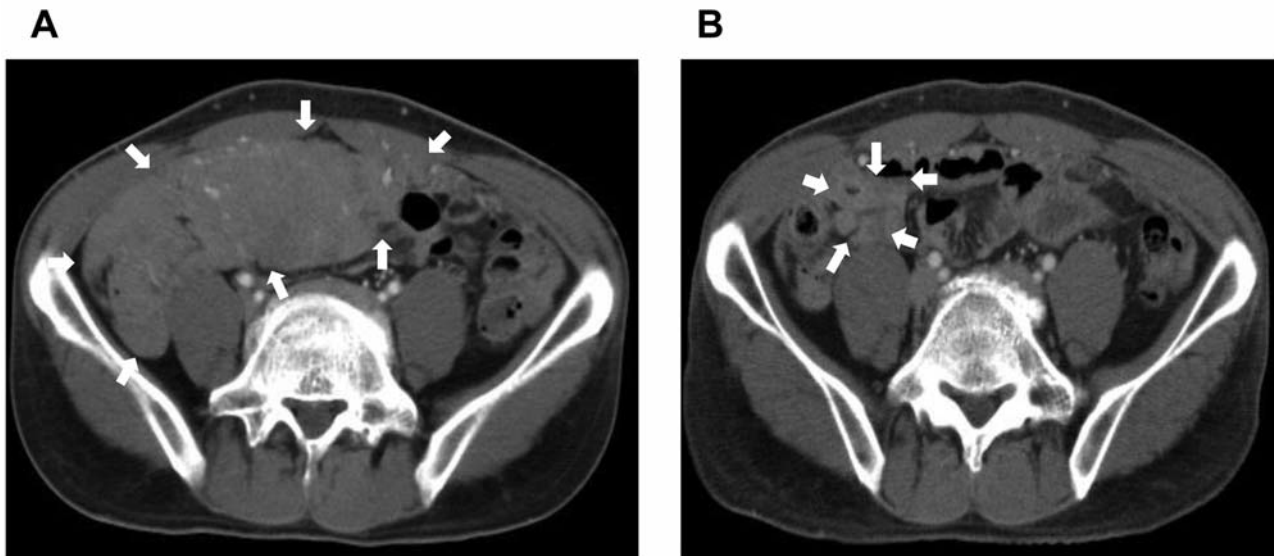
Representative abdominal computed tomographic (CT) images of patient 4 are shown. The partial response of the tumor was revealed by CT images before (A) and after (B) six cycles of chemotherapy. Arrows indicate the abdominal tumor.
